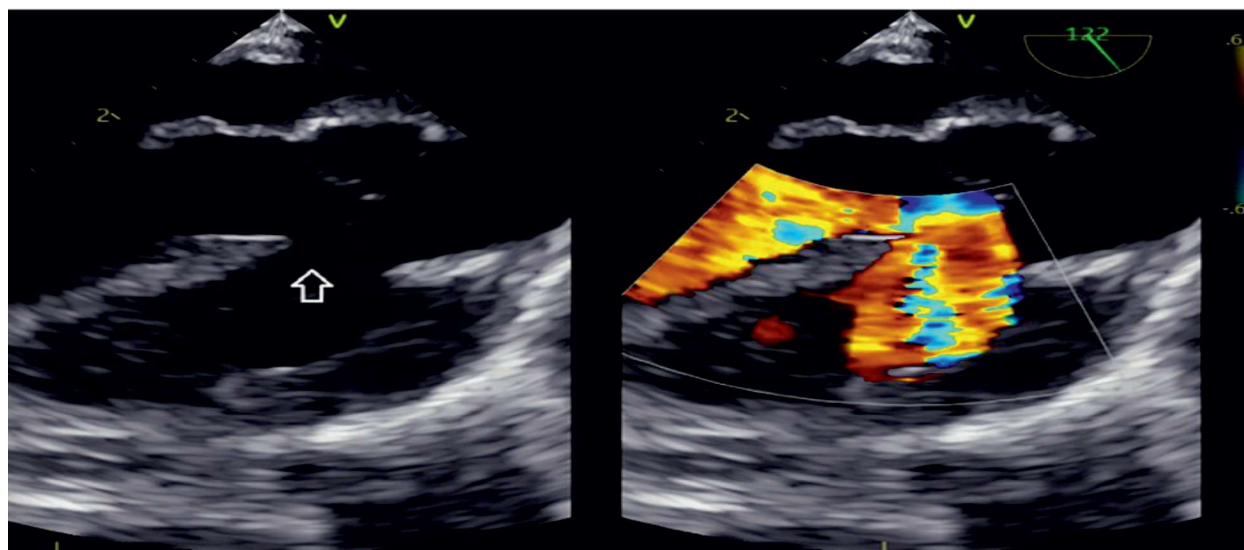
A simultaneous color doppler image showing mid-esophageal aortic valve long axis view, with the arrow pointing toward the sub-aortic VSD and shunt flow
